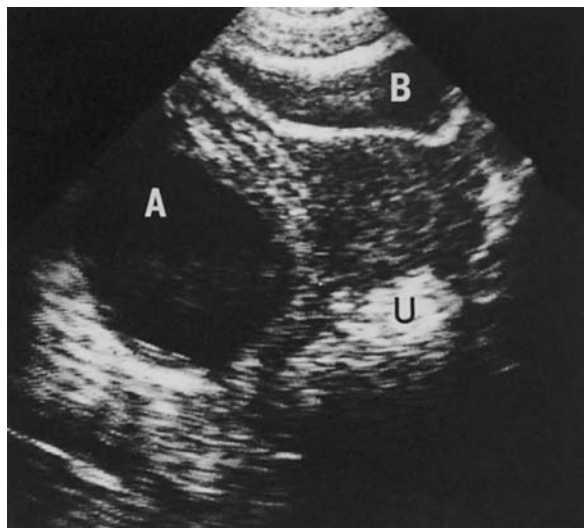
Transverse real-time sonogram of the pelvis of a 15-year-old patient with gonococcal salpingitis, demonstrating a 6 × 8-cm right tuboovarian abscess (A) containing a fluid-debris level. U, uterus; B, bladder.
